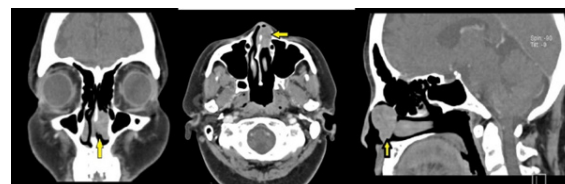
Computed tomography of the paranasal sinus showed an enhancing soft tissue density lesion at the proximal left nasal cavity, measuring $2.4 \times 1.8 \times 2.7$ cm with thinning of the adjacent left nasal bone (Arrows)
